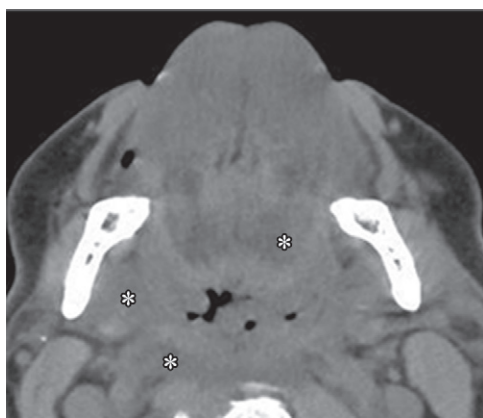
Acute-onset tongue swelling resulting from angioedema in a 14-year-old adolescent girl. Axial noncontrast CT image shows trans-spatial edema (*) involving the sublingual, submandibular, parapharyngeal, and retropharyngeal spaces and resulting in marked narrowing of the airway. Intramuscular edema within the tongue contributes to the tongue protrusion.
